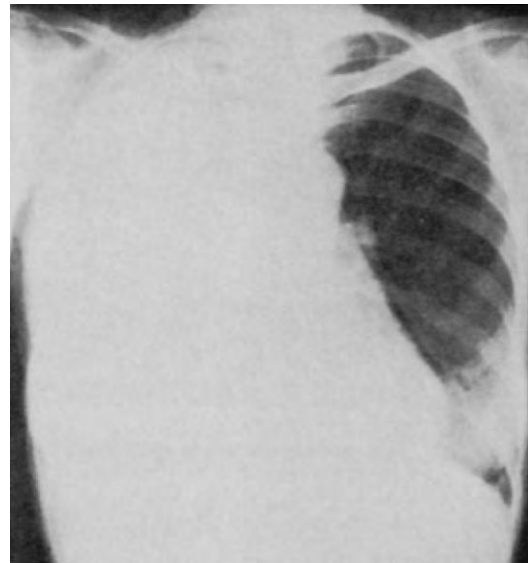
Chest radiograph of a patient with chronic massive right-sided pancreatic pleural effusion. (From Cameron JJ, Kieffer RS, Anderson WJ, et al: Internal pancreatic fistulas: Pancreatic ascites and pleural effusions. *Ann Surg* 184:587, 1976.)
